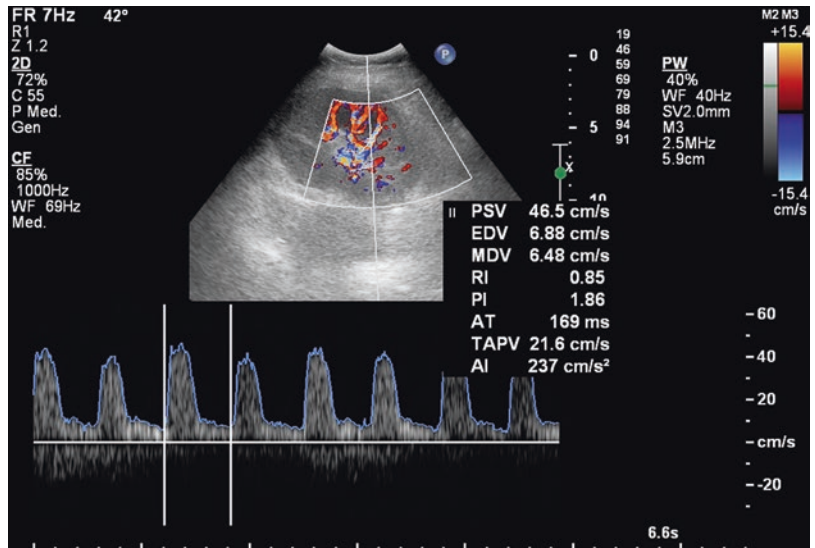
CDUS: transplanted kidney with regular morphology and Doppler spectra increased (RI 0.85)
